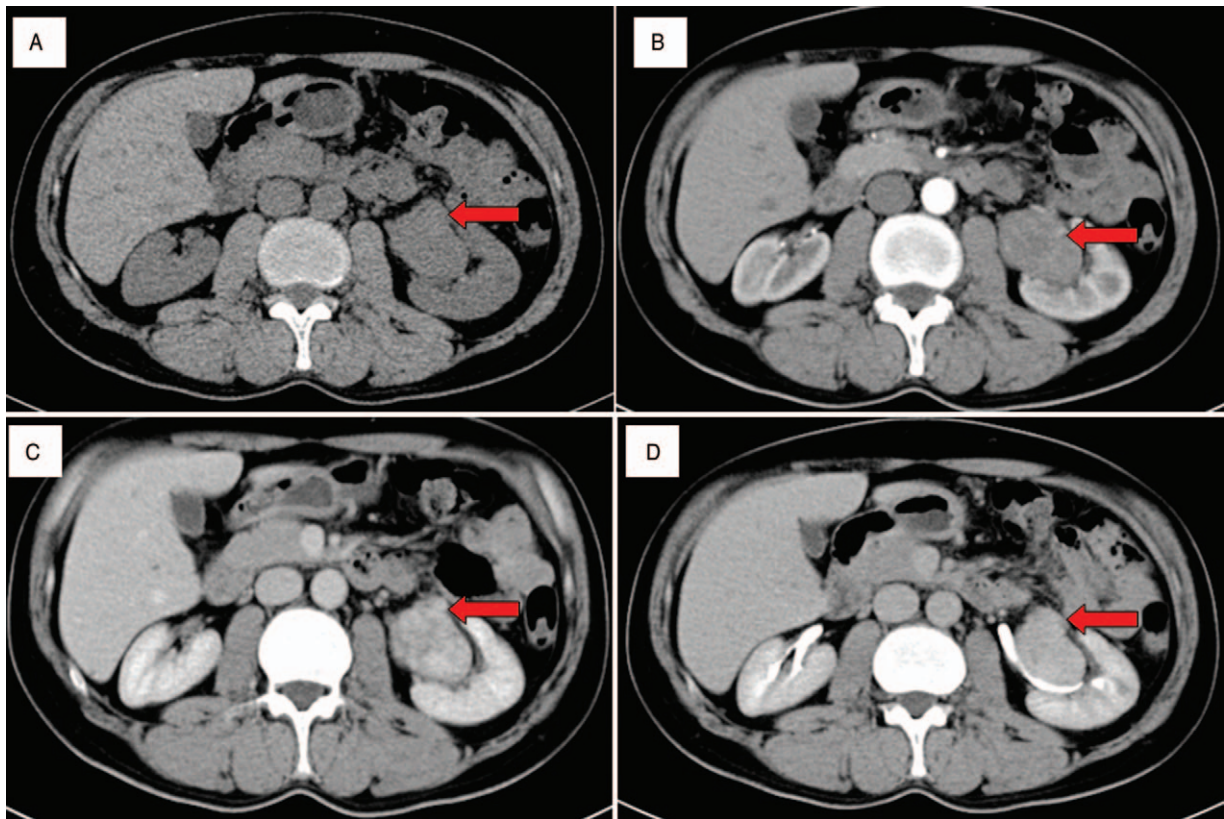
(A) Computed tomography image showing a homogeneous soft tissue mass (red arrow) located within the left kidney in the pre-contrast phase. (B–D) With contrast, the arterial, venous and excretory phases show a well-circumscribed, solid, homogeneous, low-enhanced mass (red arrow) in the left kidney.
